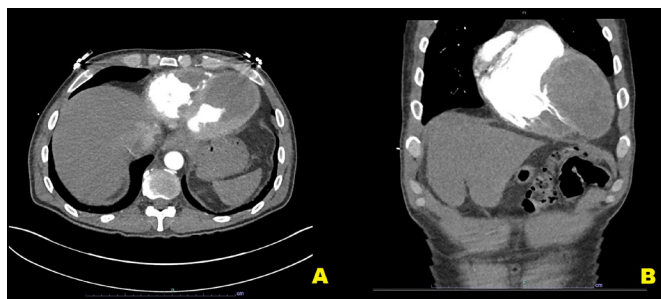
CT of the (A) chest and (B) abdomen noting biventricular thrombi obscuring most of the ventricles.
